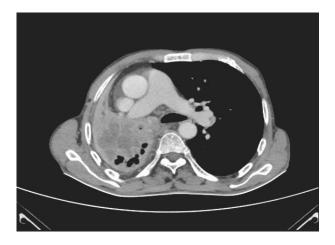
(a): Axial CT shows infiltrative mass right hilar causing occlusion of right main stem bronchus.
